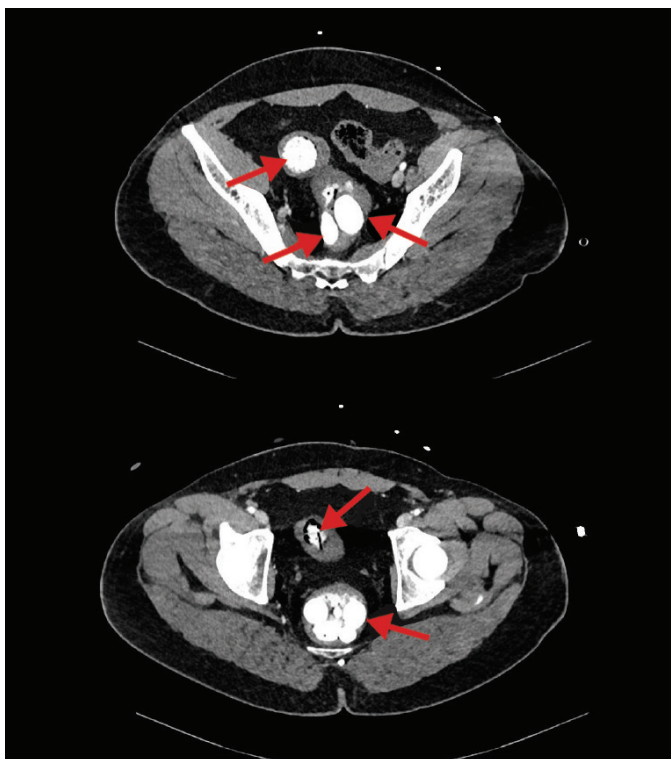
Hyperdense findings consistent with foreign bodies in computed tomography scan images (red arrows: packets)
